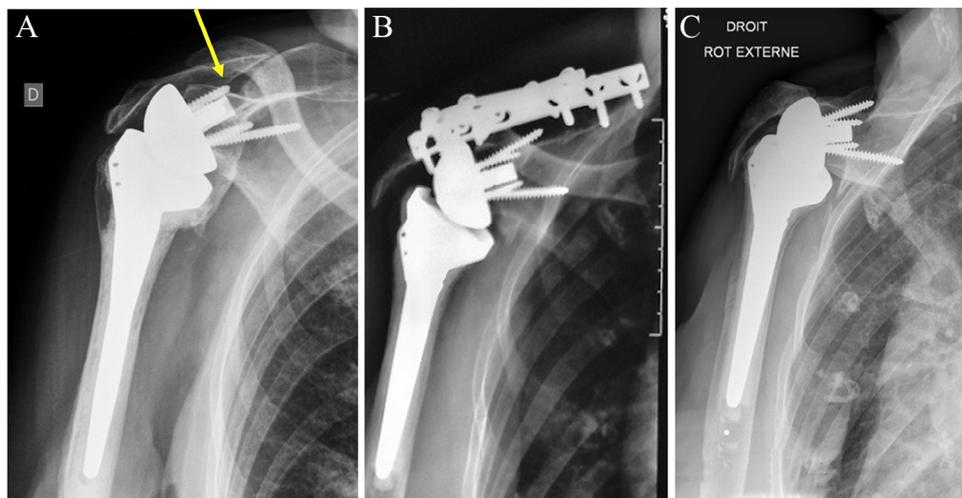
(A) An 81-year-old woman underwent reverse shoulder arthroplasty for cuff tear arthropathy on her right shoulder. Radiographs 8 months after the procedure demonstrate a fracture line in relationship with the tip of the superior screw (*arrow*). (B) Open reduction and internal fixation was performed with 2 perpendicular AO (Arbeitsgemeinschaft für Osteosynthesefragen) plates. The nonunion remained, and the hardware was removed 21 months after the reoperation. (C) At 7 years of follow-up, nonunion is present with downward tilt and decrease acromion-greater tuberosity distance.
